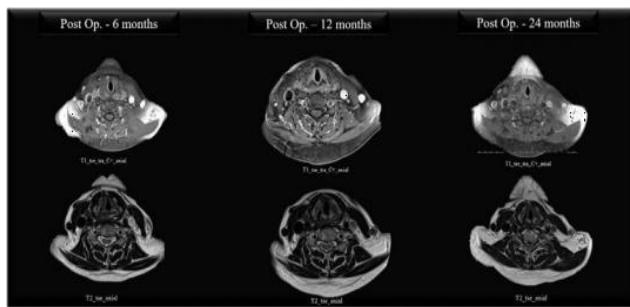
Serial post-operative MRI's at 6 months, 12 months and 24 months.
